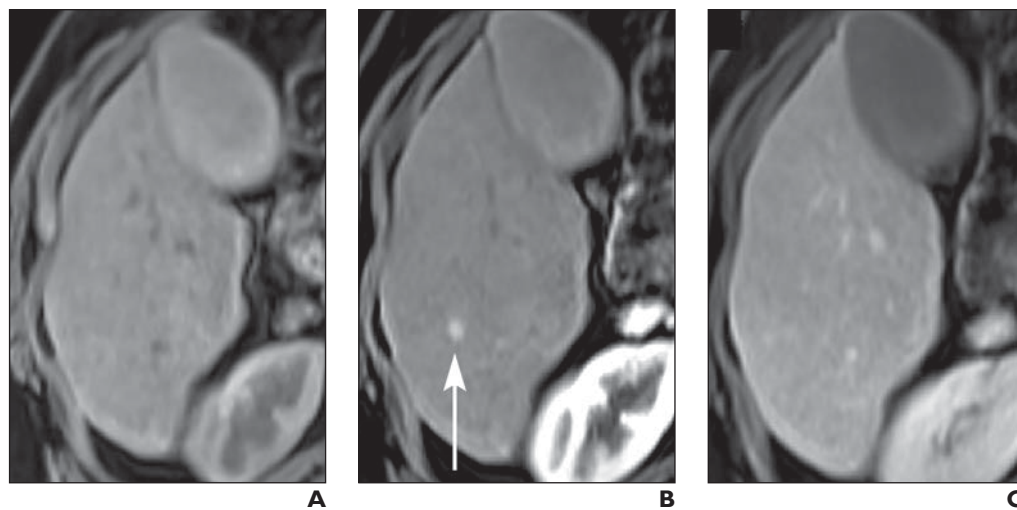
51-year-old man with hepatitis C. Typical nodulelike area of hyperenhancement (NAPH) is present on arterial phase images and was invisible in other later phases. No corresponding signal-intensity abnormalities are present on unenhanced T1-weighted image.
